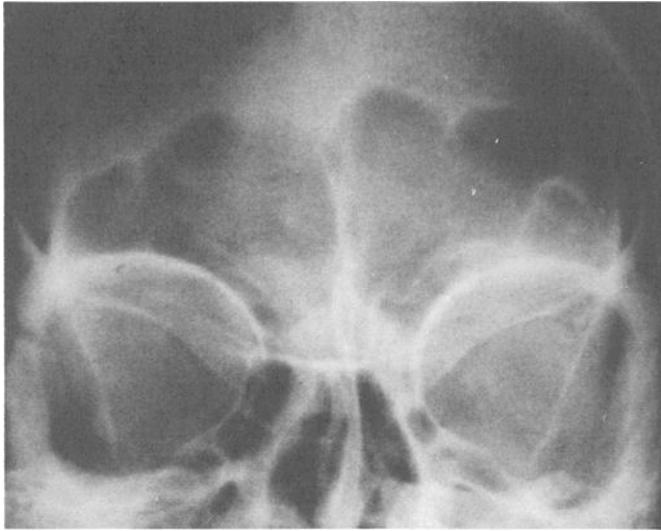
Case 2: autopsy film revealing complete concordance of the sinus outlines and septae with those in the antemortem radiograph in Fig. 3.
